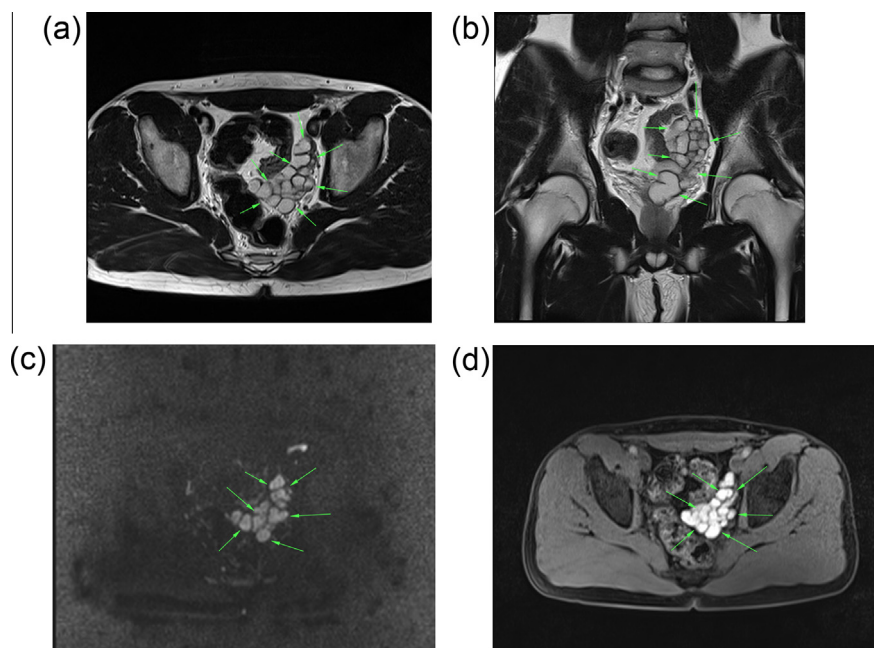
The fifteen-year-old boy with pelvic pain at magnetic resonance imaging examination; (a) axial-T2-weighted sequence shows the dilated tubular structures, (b) coronal-T2-weighted hyperintense sequence shows dilated tubular structures in the left pelvic region superior to colon segments with thin linear septations. (c) Diffusion weighted images on coronal plane sequence do not demonstrate diffusion restriction. (d) On T1-weighted contrast enhanced sequences, dilated tubular structures do not enhance after contrast enhancement in axial images. All the lesions are demonstrated by large arrows.
